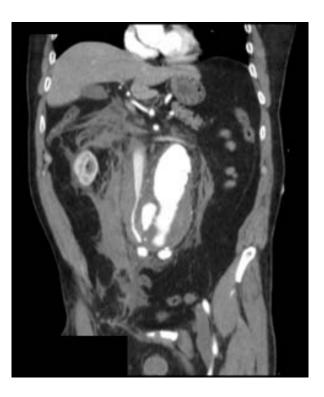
CTA demonstrating free rupture of a 7.5 infrarenal AAA with aortocaval fistula
